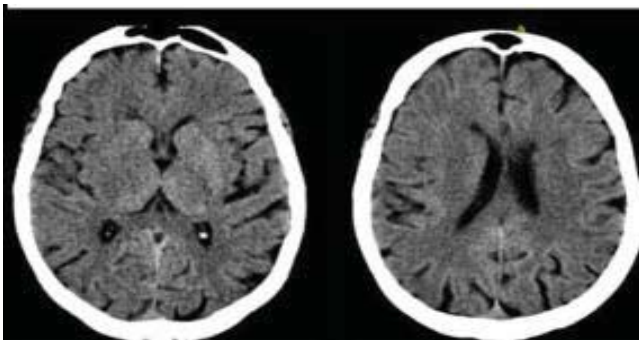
A patient with an ASPECTS score = 5.
